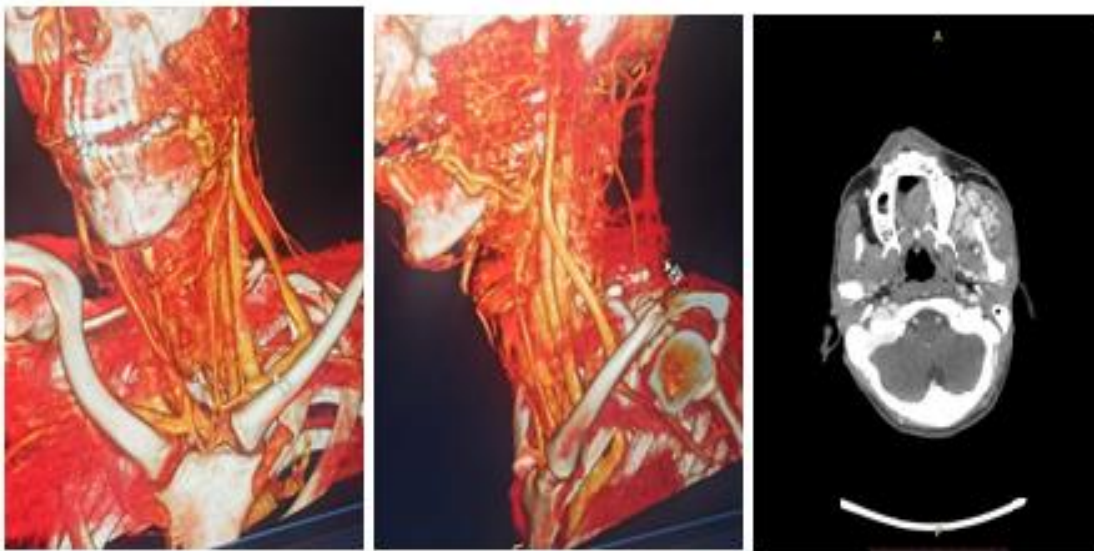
CT of head and neck: huge left mandibula AVM with multiple collateral from left and right external carotid arteries branches and left thyroid artery.
